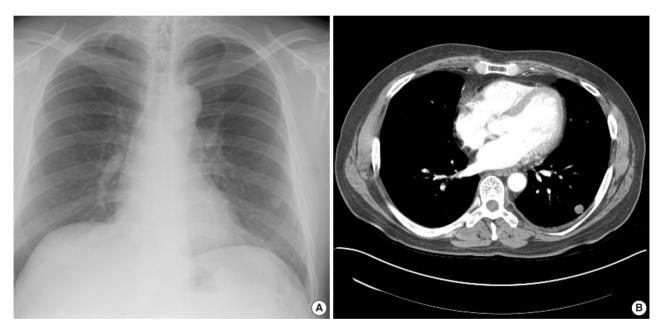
Coin-like nodule with a sharp outline was revealed in the left lower lobe by chest radiography (A), and chest computed tomography (CT) visualized a well defined small round nodule in left lower periphery (B).
